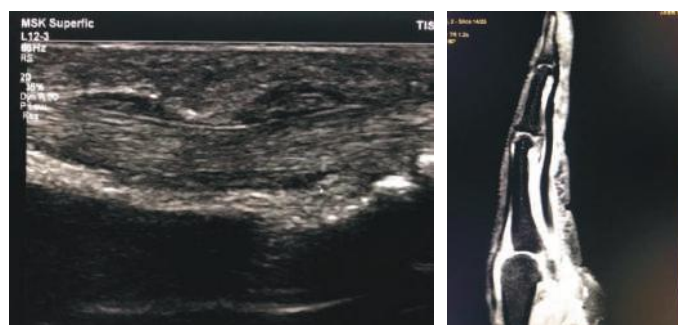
Determining the extent of disease in longitudinal plane (i) ultrasound and (ii) MRI.
